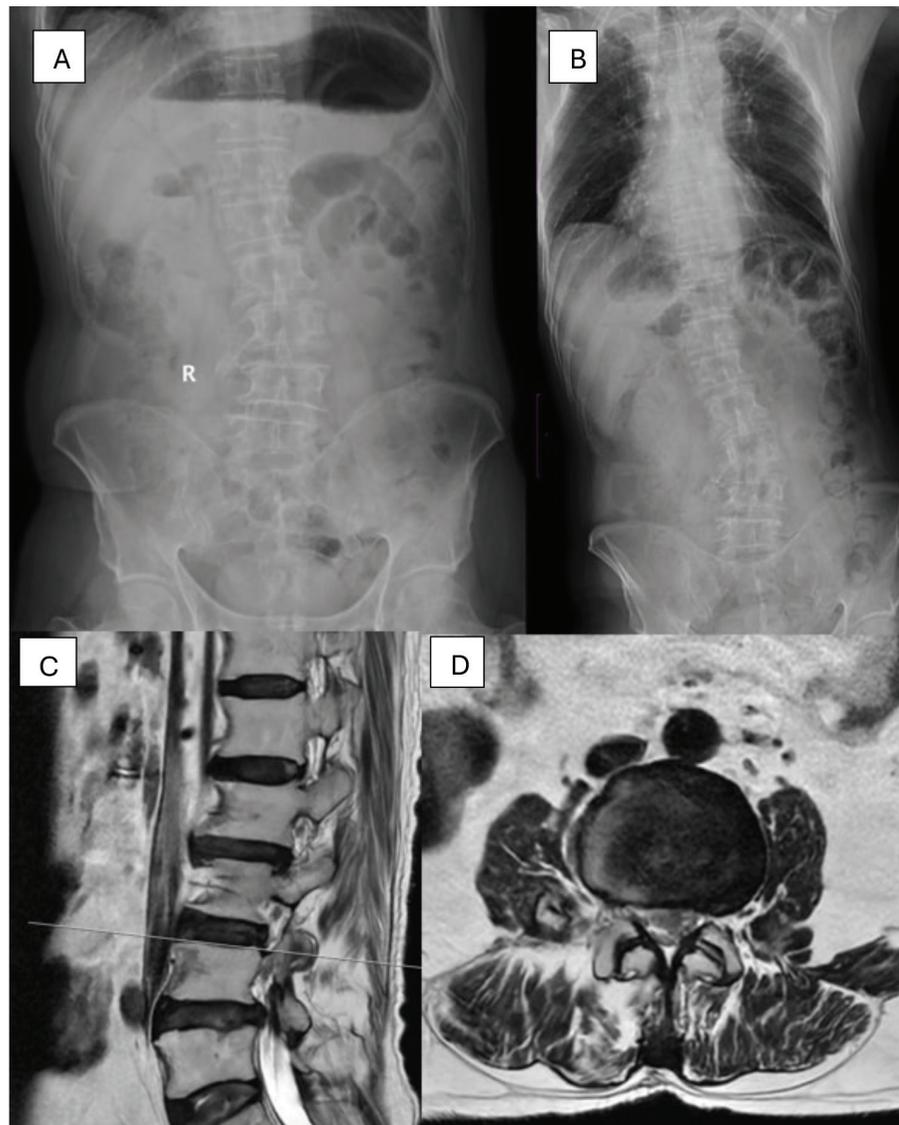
A and B; Simple anteroposterior radiograph shows osseous bridging between the right transverse processes of L3 and L4 vertebrae along with minor scoliosis and narrowing of the disc space. C and D) Sagittal and axial T2-weighted MRI of the lumbar spine disc herniation at L3-L4 level
